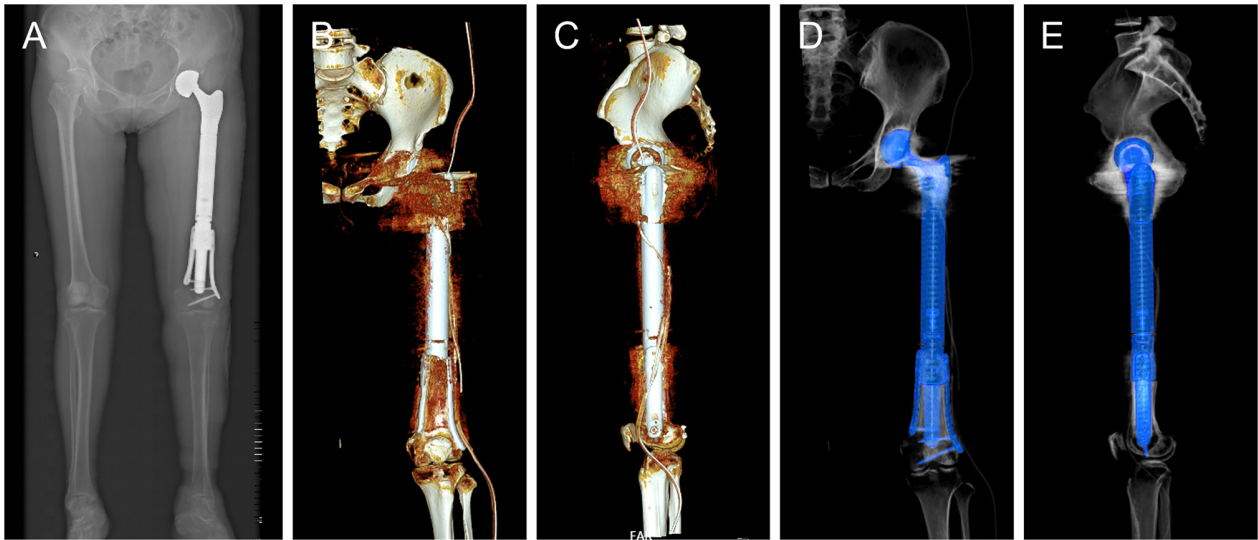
Postoperative imaging at day 3. (A) X-rays showed satisfactory positioning of the 3D-printed distal femoral prosthesis and modular tumor-type hemi-hip prosthesis. (B) Coronal 3D CT reconstruction shows stable fixation of the prosthesis to the residual femur. (C) Sagittal 3D CT reconstruction confirms excellent apposition and stable fixation between the implant and residual femur. (D) Coronal 3D CT with segmented blue-colored prosthesis visualizes satisfactory prosthesis position and stability. (E) Sagittal 3D CT with segmented blue-colored prosthesis visualizes secure fixation of the implant.
